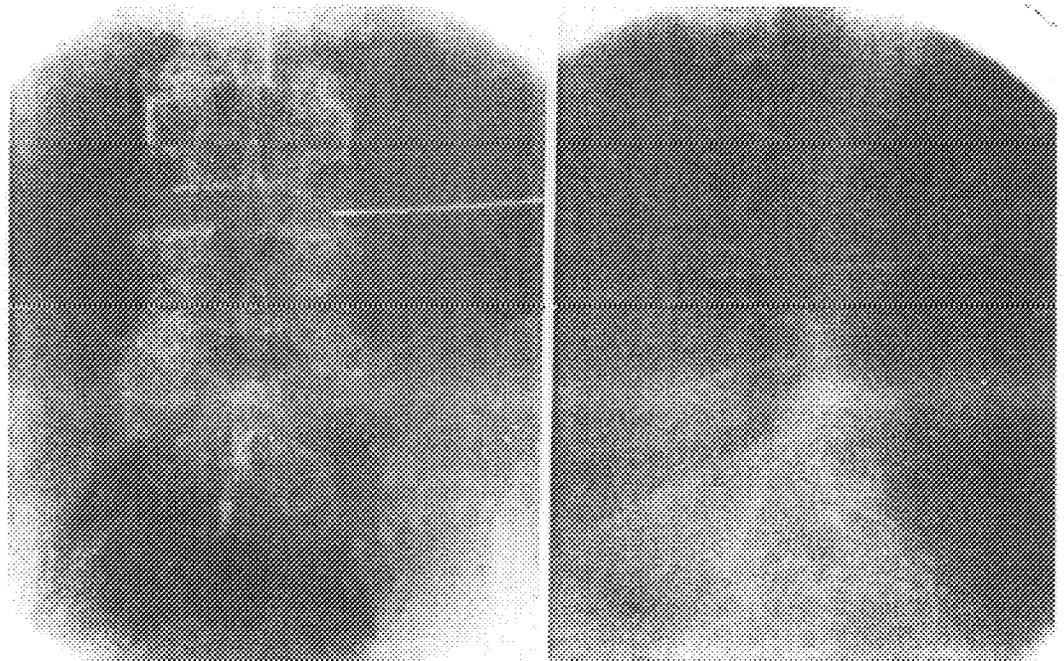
Anteroposterior and lateral roentgenograms showing correct position of needle at L4-L5.
